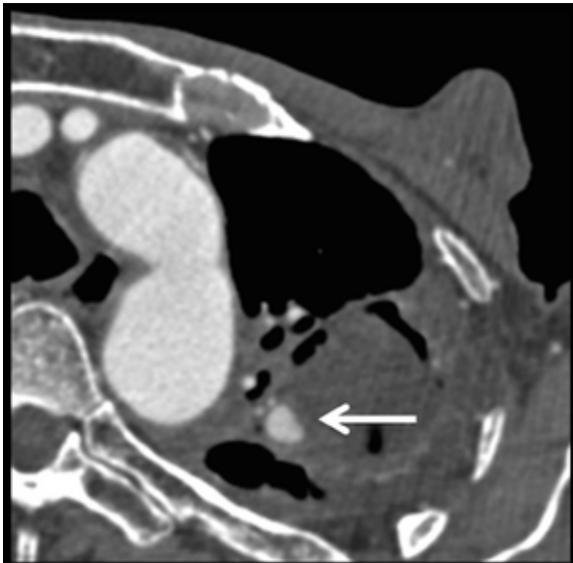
Contrast-enhanced CT shows the pulmonary artery pseudoaneurysm (PAP) due to pulmonary aspergillosis in the left upper lobe (arrow).
